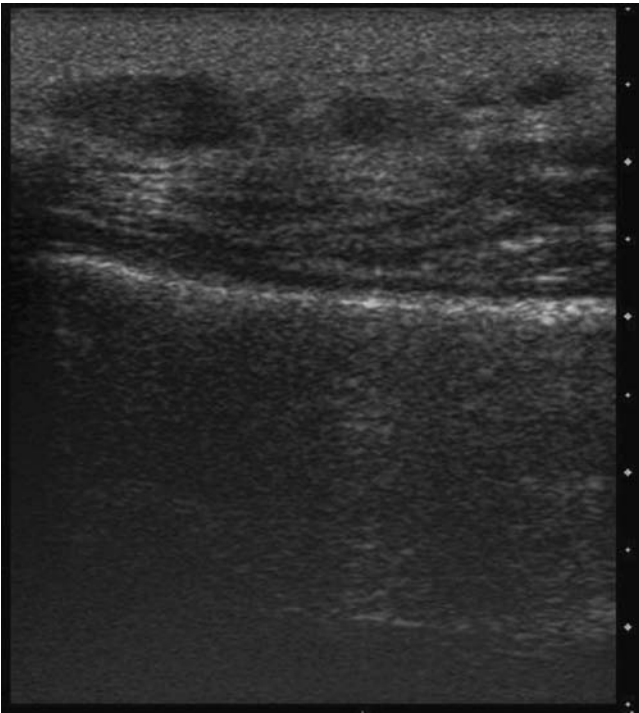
Ultrasound evaluation was carried out using a 10 MHz linear probe and showed multiple isolated hypoechoic, heterogeneous lesions with posterior enhancement in the subcutis.
